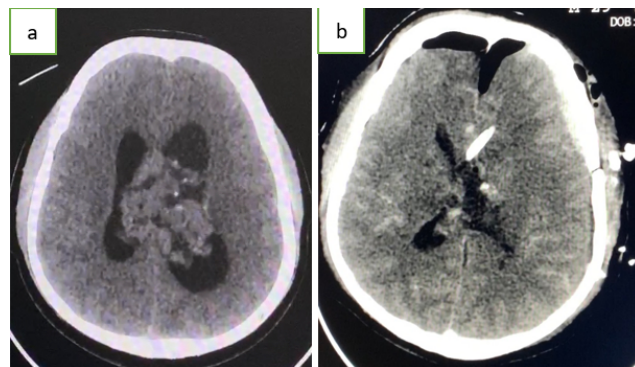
a: CT brain was showed ill-defined lesion in the lateral ventricles; b: Transcortical approach total excision of the lesion was done with EVD insitu.
